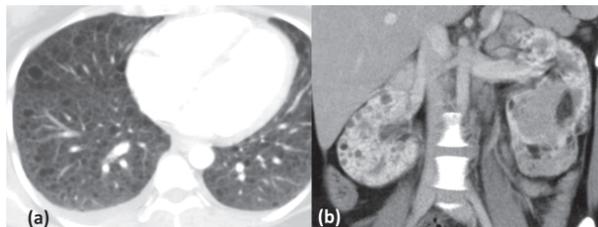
(a) Axial CT section in lung window shows multiple cystic lesions in both lungs. The lucent areas are having a well-defined wall, favouring a diagnosis of cyst.
